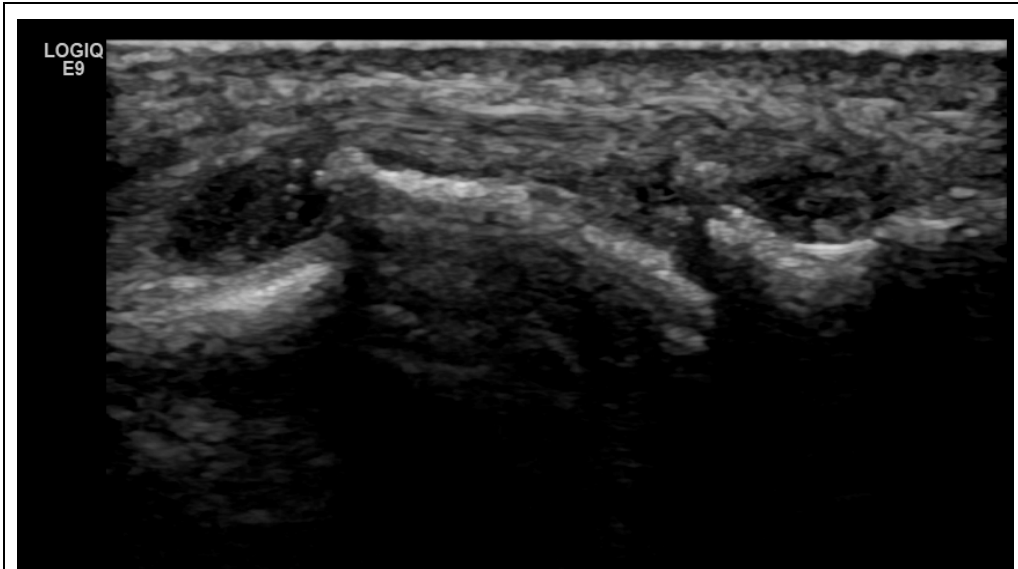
Ultrasound image shows an osteophyte at the bony margin of an MTP joint on longitudinal view.
